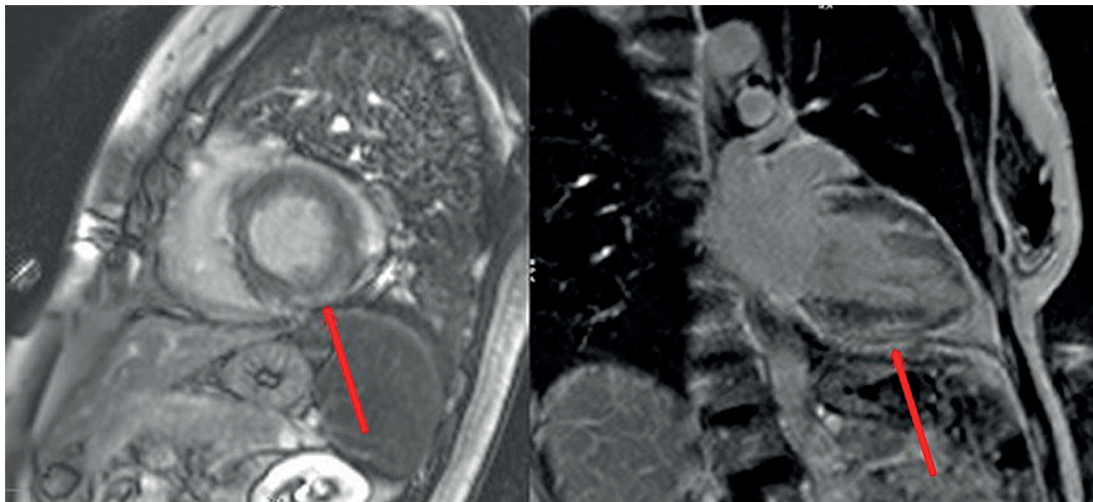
Cardiac MRI showing edema and multifocal late enhancement of nonischemic meso subepicardial pattern, with predominance in the inferoseptal, inferior, and mid-basal inferolateral left ventricle, compatible with inflammatory cardiomyopathy (red arrows).
